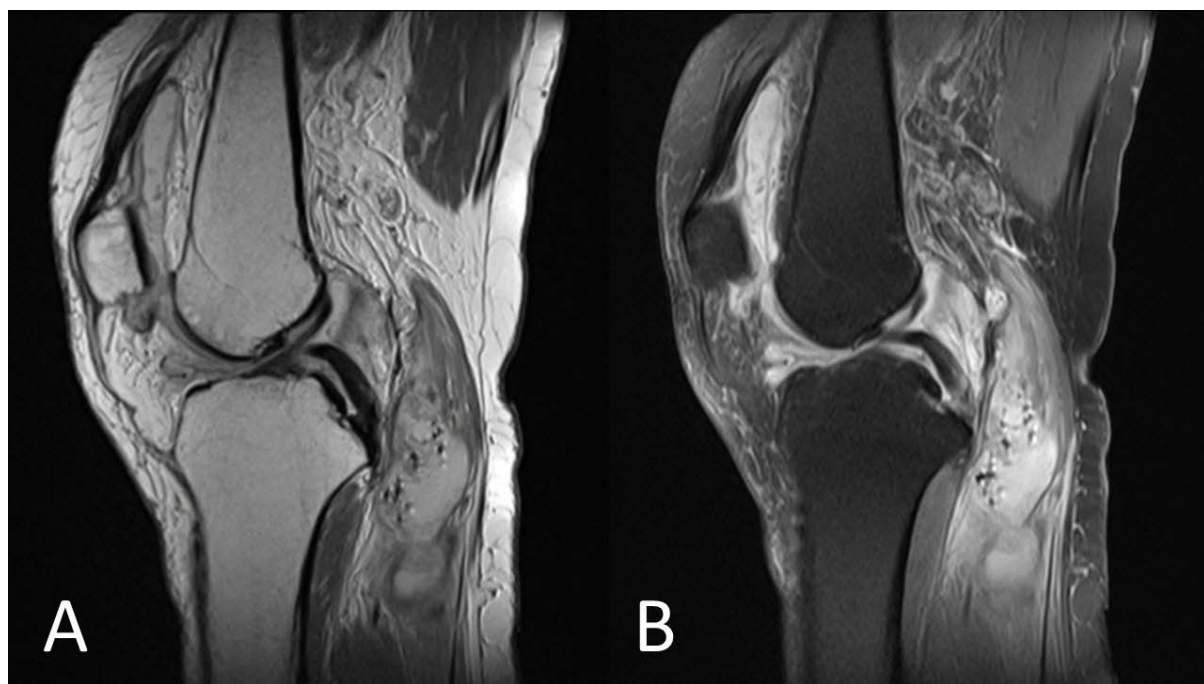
Sagittal PD (A) and PD FS (B) of the right knee showed a popliteal cyst with multiple round hypointense foci - correlating to recent radiographic appearance of gas locules.
